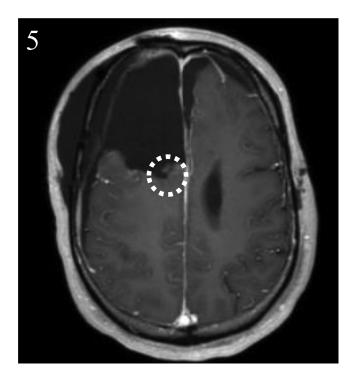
Postoperative MRI after second surgery. The enhanced lesion disappeared on contrast-enhanced MRI (area enclosed by dotted circle).
